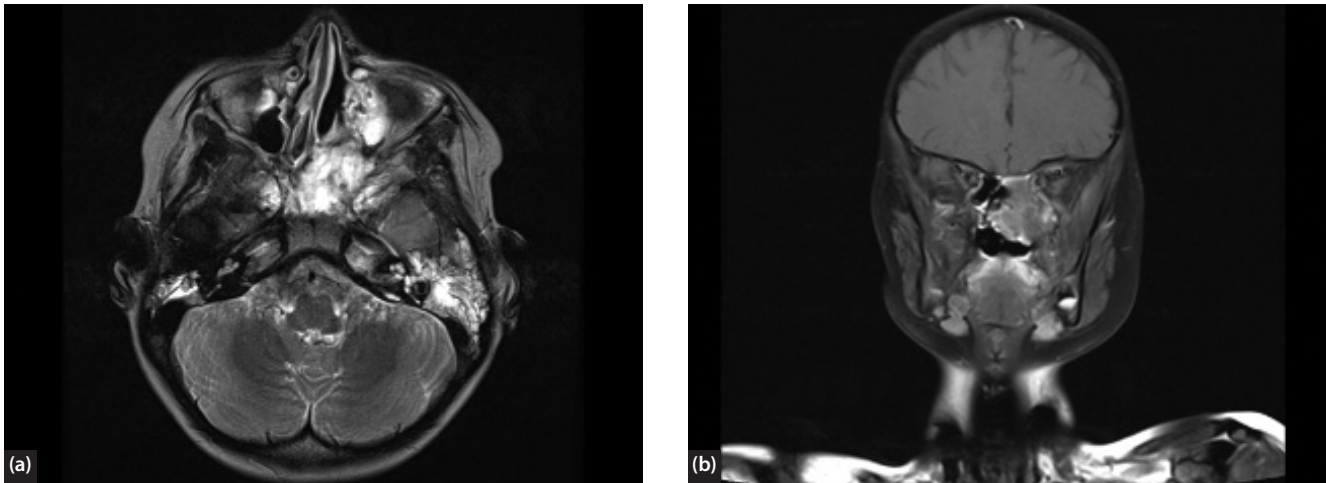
(a) Axial MRI and (b) coronal MRI showing nasopharyngeal rhabdomyosarcoma displacing the parapharyngeal fat space laterally. Opacification of right middle ear and mastoid air cells is also seen.
